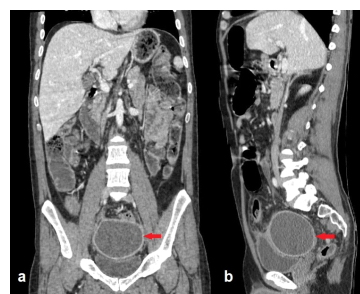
a,b. Coronal (a) and sagittal (b) post -contrast abdominopelvic computed tomography sections show that the hydatid cyst fills the rectovesical pouch and compresses the bladder (arrows). There is no evidence of infiltration in the adjacent structures of the cyst. Note that there is no additional cystic lesion in the abdominopelvic cavity.
